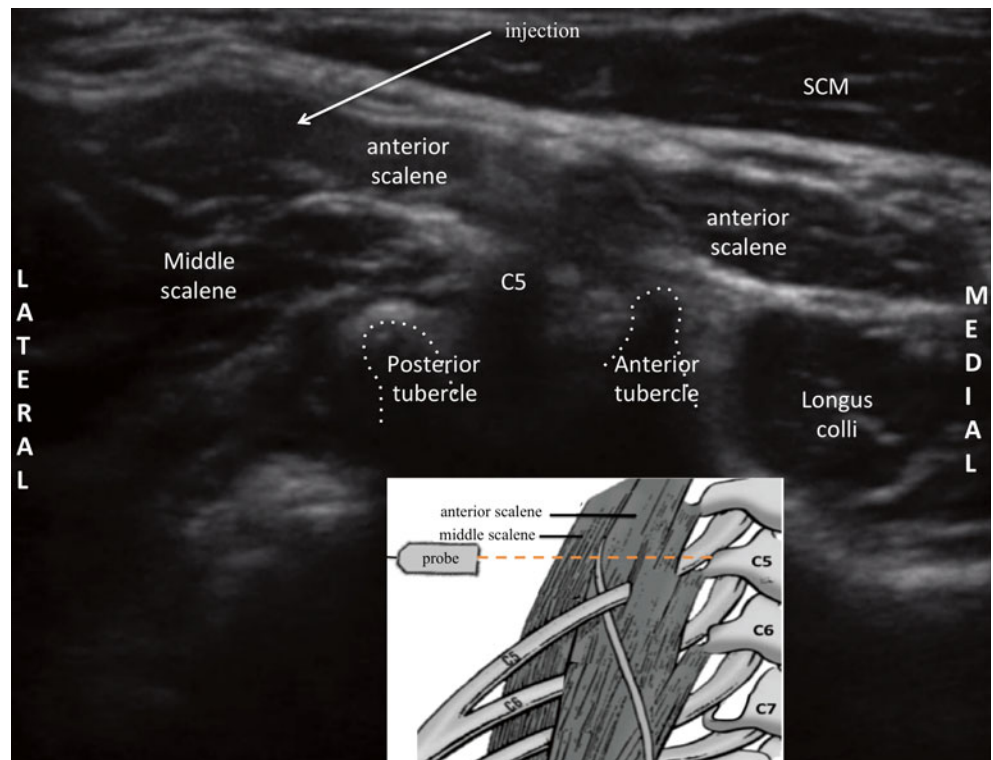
Peripheral nerve stimulation of the brachial plexus placed under ultrasound guidance (Image courtesy of Christ DeClerck, MD)
